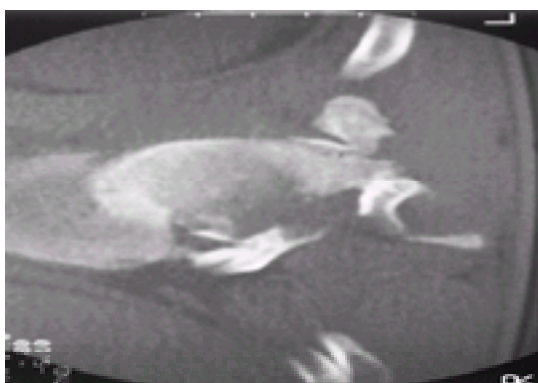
CT scan showing marked dislocation of T7 on T8.
